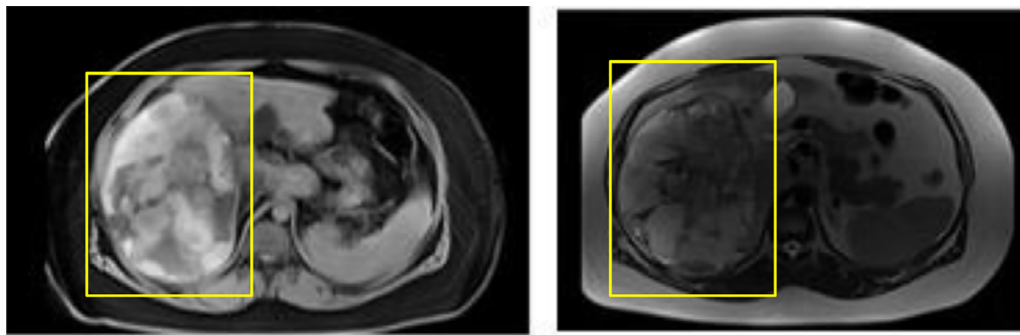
MRI T1 on the left and T2 on the right showing large hepatic mass with complex internal fluid collections and some solid components (yellow rectangles).
